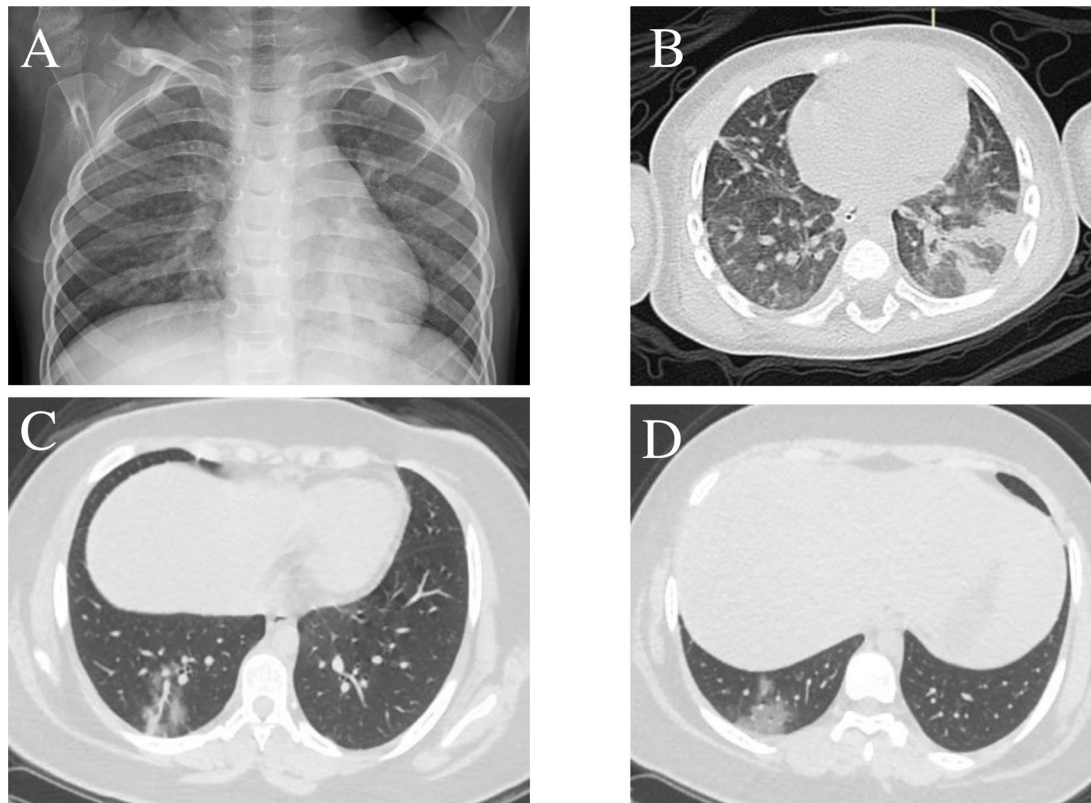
Chest radiograph and CT images of representative patients. Typical changes include ground glass opacities especially in the peripheral lung fields (panels B, C, D). Radiograph showing interstitial infiltrates (A).
